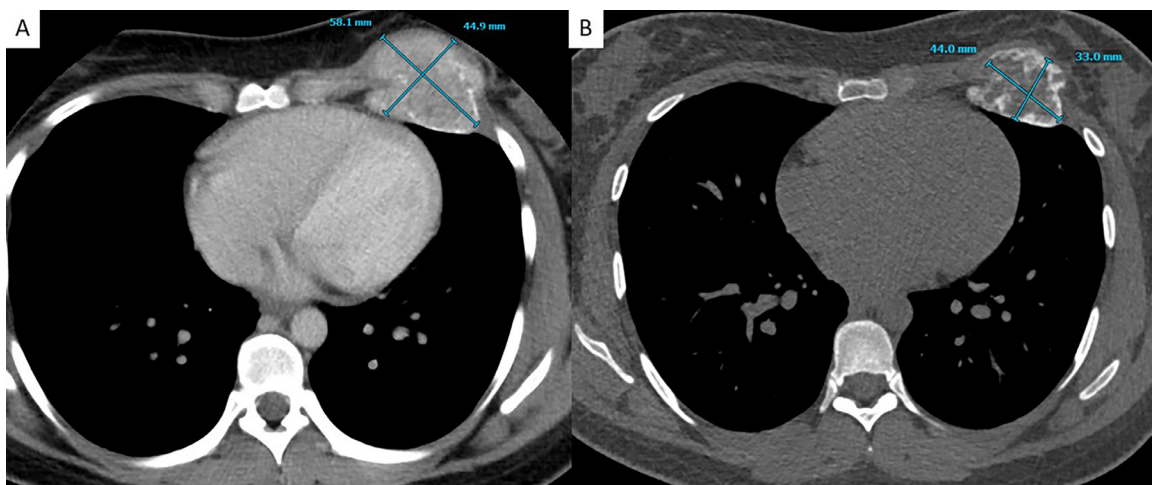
Initial axial CT of the mass (A) compared to axial CT of the mass taken 3 months later after 3 cycles of denosumab (B), demonstrating decrease in size from 5.8 × 4.5 cm to 4.4 × 3.3 cm as well as increased peripheral sclerosis.
